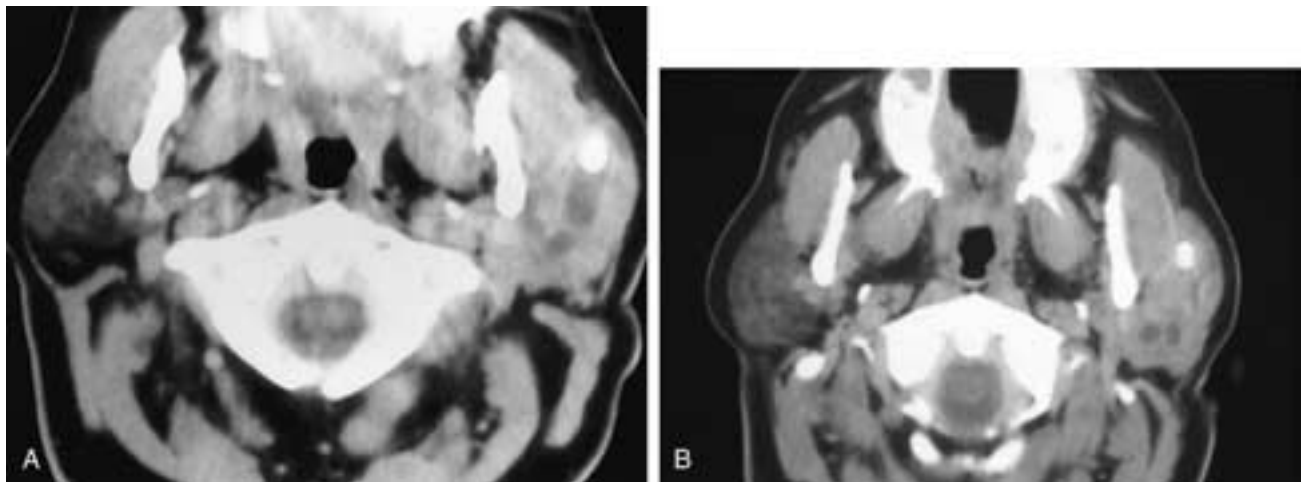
Axial CT scans (A, B) on two different patients. In A, there is a calculus in the hilum of the left parotid gland. Mucoid secretions are present in the dilated intraparotid central duct. The left parotid gland is diffusely denser than the normal right gland. In B, there is a calculus in the left parotid hilum, and dilated ducts are seen within the gland. The left parotid gland is also denser than the normal right parotid gland. Both of these patients had acute sialadenitis and sialolithiasis.
